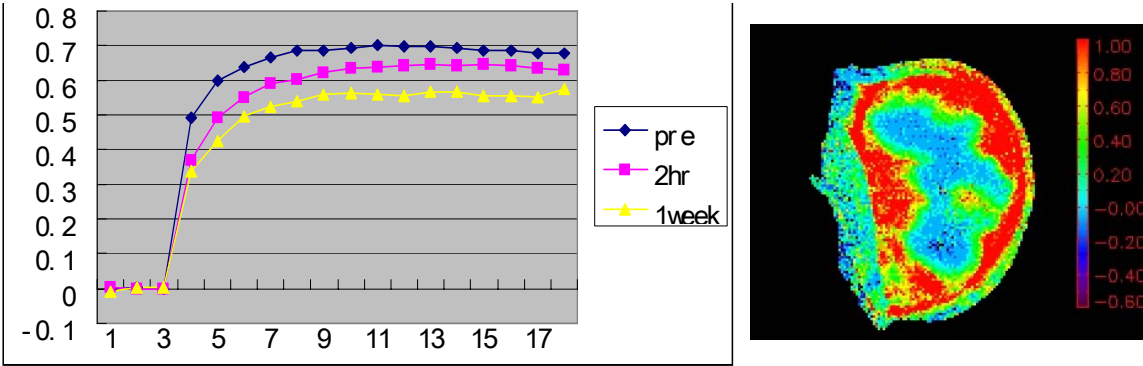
DCE for HI tumor. Left Mean signal intensity kinetics following infusion of contrast agent. Right: Relative signal intensity map for T1 weighted MRI 2 h post therapy (4 minutes after contrast agent) showing heterogeneous perfusion.
